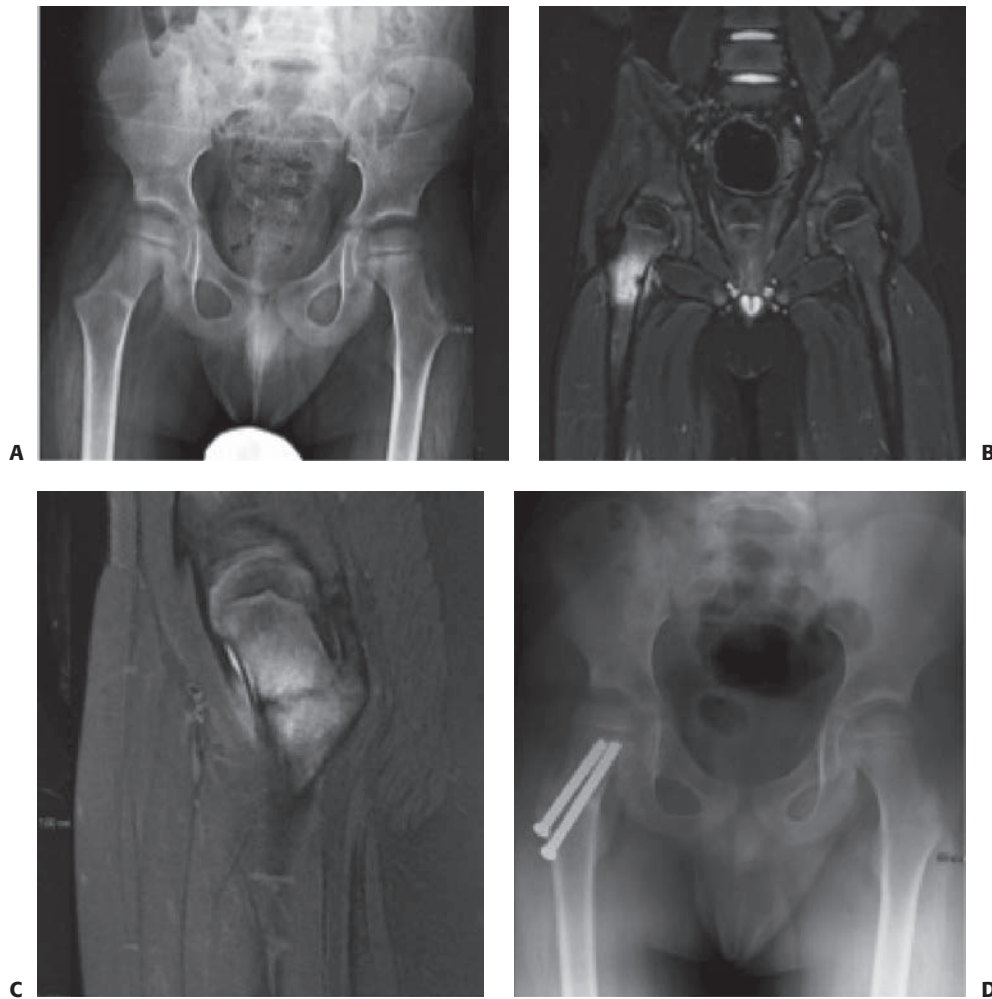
A: AP pelvis including both hips 1 week after onset of right knee pain demonstrating sclerosis at the inferior portion of the right femoral neck. B and C: MRI demonstrates a propagating fracture prompting (D) surgical fixation to prevent complete fracture and displacement. (Property of UW Pediatric Orthopaedics.)
